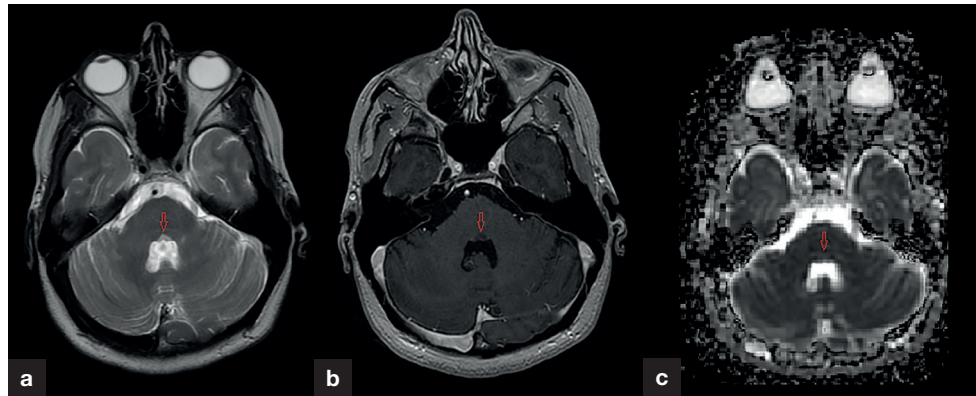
a. Axial magnetic resonance imaging T2 sequence demonstrates a triangular and symmetrical hyperintensity (arrow) in the dorsal aspect of the lower pons. b. There is no pathological enhancement (arrow) on a T1 post-contrast acquisition. c. Apparent diffusion coefficient map through the region of concern does not reveal restricted diffusivity (arrow).
